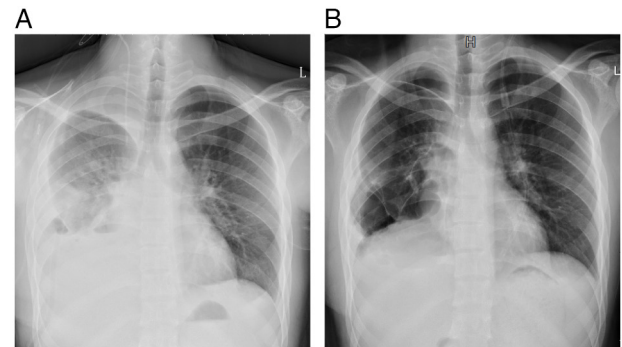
Results of the chest radiographs on day (A) 2 and (B) 10 after surgery showed a better recovery of the chest cavity. R, right; L, left.
